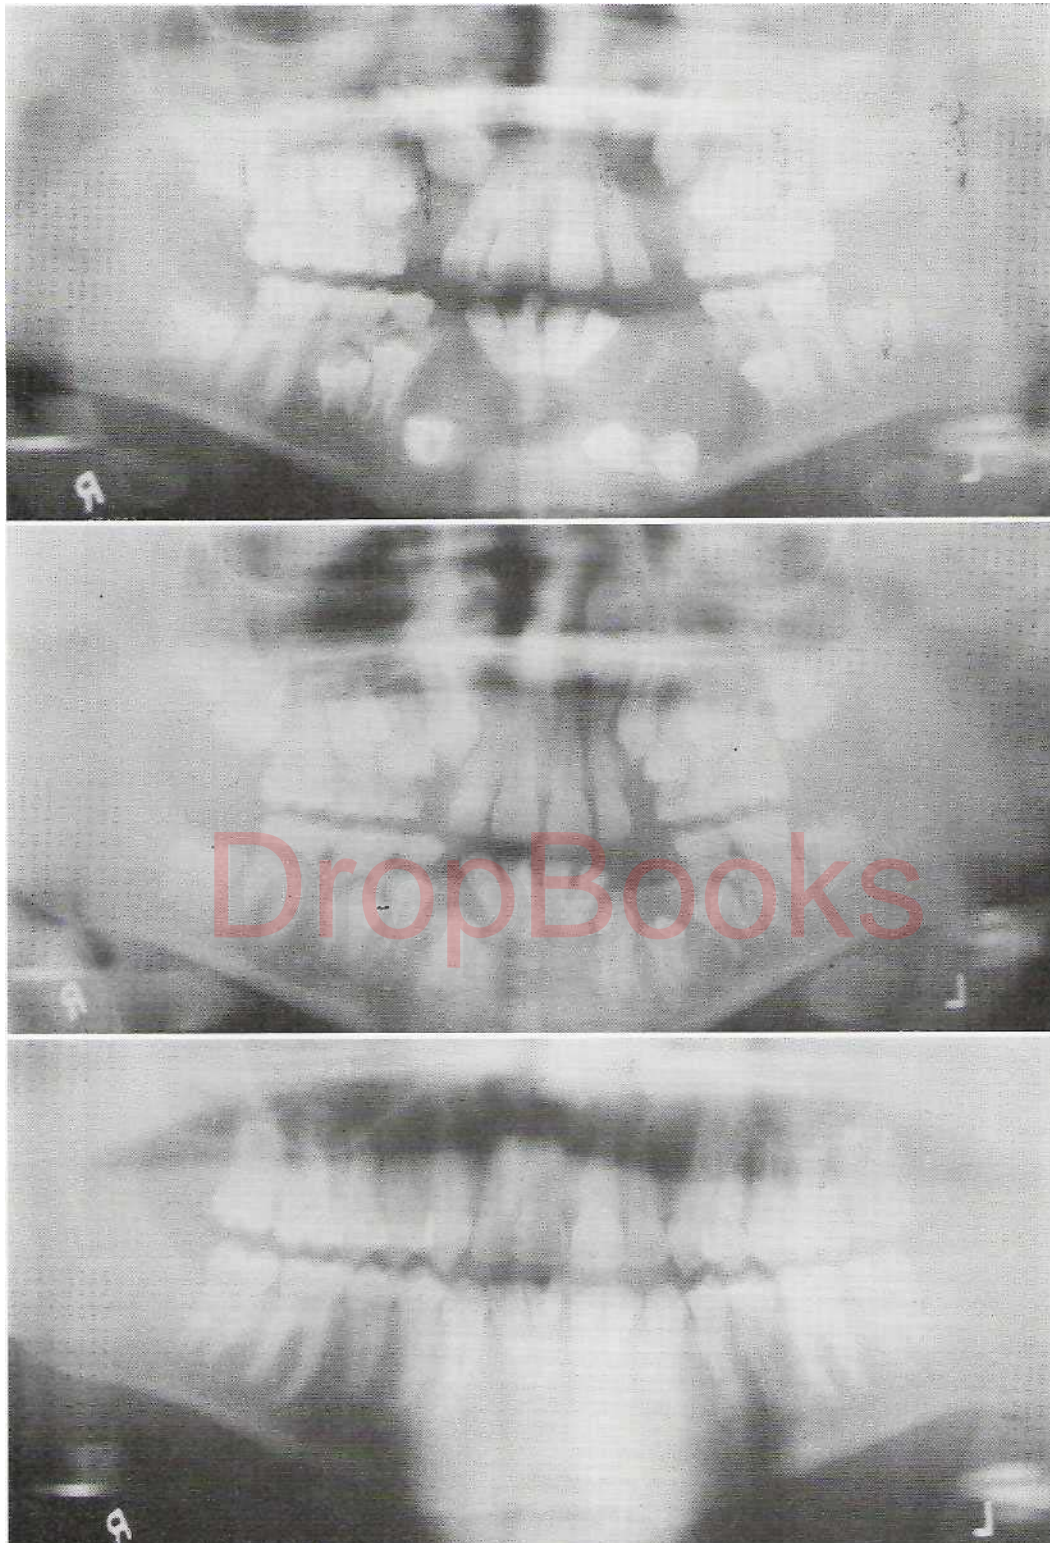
Marsupialization of multiple dentigerous cysts. A, Radiographic appearance before marsupialization. Marsupialization was carried out along crest of alveolar process on both sides. B, One year later, the uprighting and eruption of teeth are demonstrated. C, Three years later. No orthodontic assistance was required. (From Ellis E, Fonseca R): Therapy of cysts and odontogenic tumors. In Thawley SE et al, editors: *Comprehensive management of head and neck tumors*, ed 2, Philadelphia, 1999, WB Saunders; courtesy Dr. Timothy Pickens, Ypsilanti, MI.)
